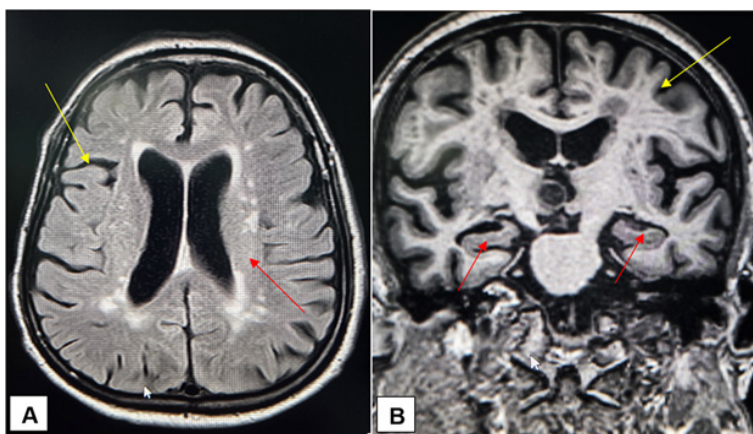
Non-contrast MRI of the patient's brain showing generalised cortical atrophy (yellow arrows) and loss of hippocampal volume (red arrows) in (A) FLAIR image and (B) Coronal T1 image of the patient's brain. These structural changes were consistent with neurodegenerative patterns observed in Alzheimer's disease.
